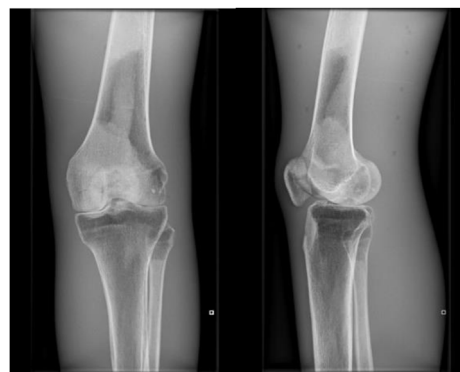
Images produced using the modified 10 kV (75 % decreased mAs) AP and Lateral knee X-rays.
